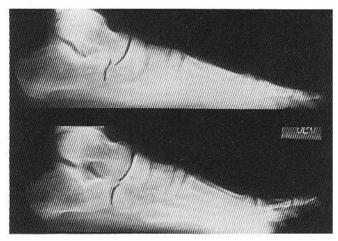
(Top) In a pronated foot x-ray, the talonavicular joint "appears" much more anterior than the calcaneal cuboid joint, as the lateral silhouette of the talus becomes more prominent, this creates an anterior break in the cyma line. The lateral wall of the posterior subtalar joint facet rotates forward, occluding the sinus tarsi, causing a + Kirby sign. (Bottom) In a supinated foot x-ray, as the talus abducts, the talonavicular joint "appears" much more posterior than the calcaneal cuboid joint, as the talar silhouette becomes less longitudinal, this creates a posterior break in the cyma line. The lateral wall of the posterior subtalar joint rotates backward, uncovering the sinus tarsi, causing a more open and rounded sinus tarsi or "Bullet Hole."
